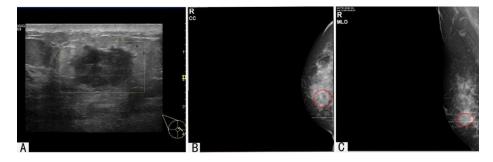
Ultrasound of the right breast (A): hypoechoic nodule with an echoless dark area visible within; Mammogram of the right breast: right CC-view (B) and MLO-view (C) showing a tissue mass (circle) in the right breast.
